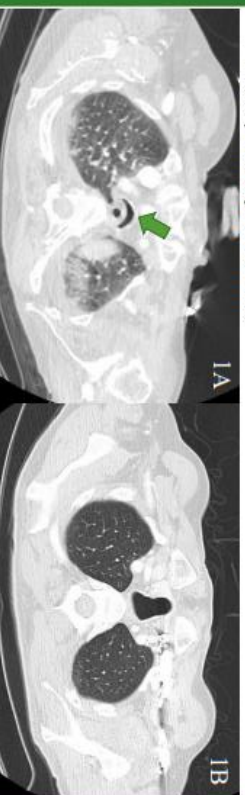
Transverse cut of CT chest (Lung Window) noting excessive bowing of membranous portion of trachea. Figure 1B- Same approximate transverse cut of a CT of same patient four years prior.
